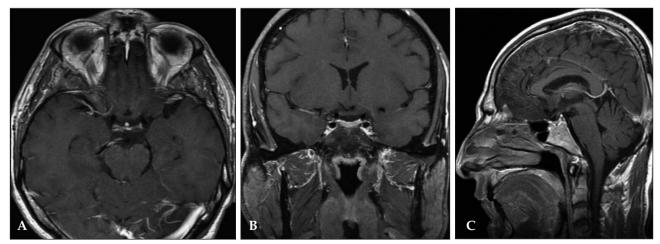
T1-weighted, gadolinium-enhanced MRI images of the second patient showing complete disappearance of the tumor at the end of the 39 months follow-up period. *A*) *Axial. B*) *Coronal. C*) *Sagittal.*
